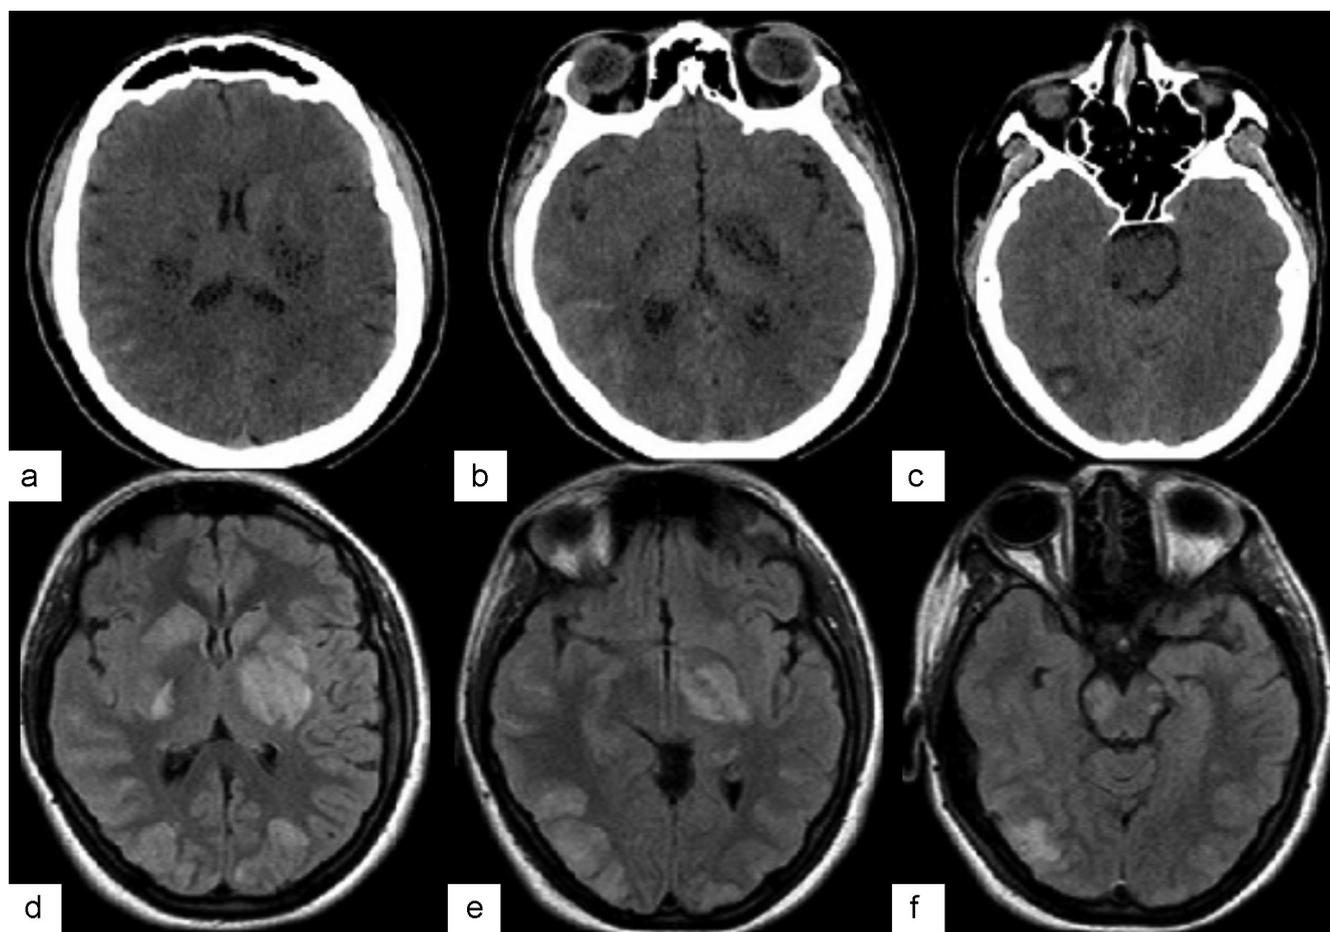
(a)–(c) Axial noncontrast CT images on the 1st day of admission reveal faint subarachnoid hemorrhage in the right temporal lobe and intraparenchymal hematoma in the right occipital lobe. (d)–(f) Axial FLAIR MR images demonstrate increased signal intensities in both of the cerebral peduncles, posterior limb of the bilateral internal capsule, left putamen, left globus pallidus extending partially to thalamus, bilateral occipital lobes, and predominantly on gray-white matter junction areas where it can be seen as low density areas on CT.
